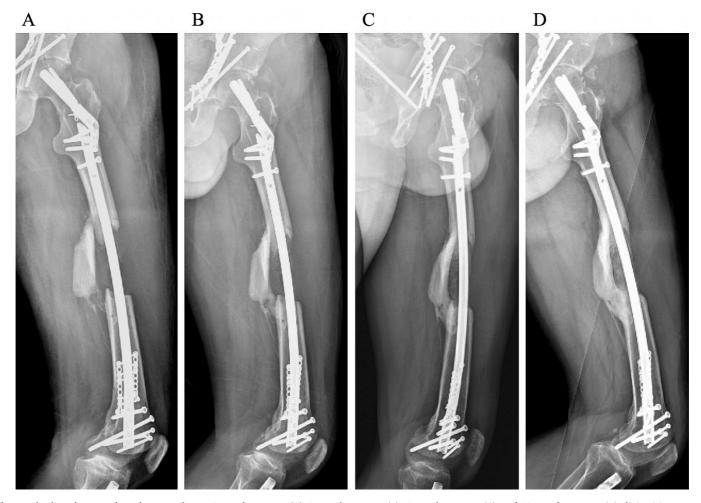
Interval fracture healing shown on lateral x-rays taken at 2 months post-op (A), 3 months post-op (B), 6 months post-op (C), and 13 months post-op (D) clinic visits. X-ray at 13 months (D) demonstrated intact hardware and well-healed femoral neck, diaphyseal, and distal femur fractures.
